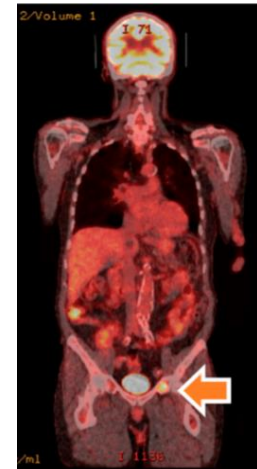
18F-FDG-PET/CT (18).
